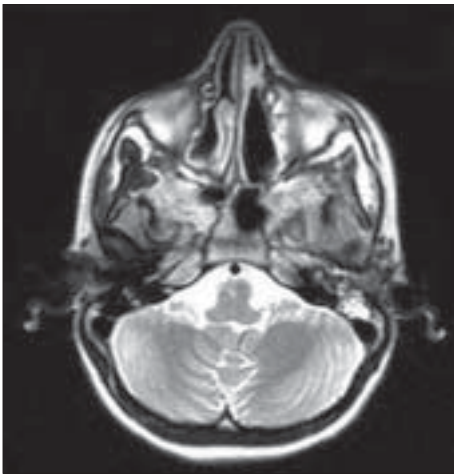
Brain MRI. Rhino-orbital-cerebral mucormycosis
